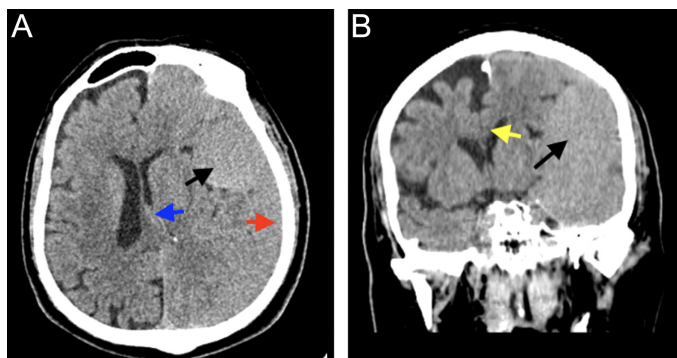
Computed tomography images at the time of admission: (A) Axial computed tomography: subacute subdural hemorrhage (red arrow) and accompanying intracystic subacute hemorrhage (black arrow), right-sided shift of midline structures (blue arrow) (B) Coronal computed tomography: subfalcine herniation to the right (yellow arrow) and accompanying intracystic subacute hemorrhage (black arrow).
